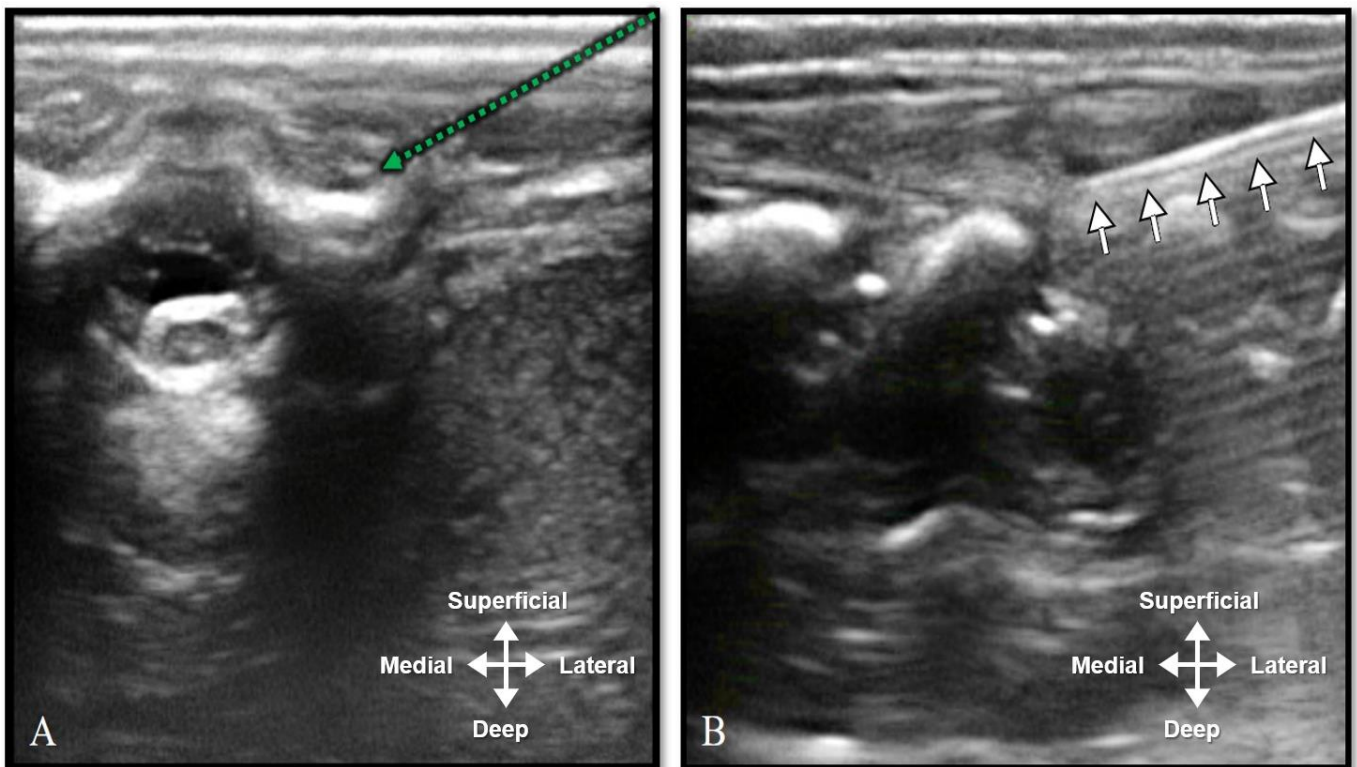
The ultrasound bony landmarks in a transverse (A) and parasagittal orientation (B) taken at vertebral level T5. The green dotted arrow represents the needle course in a transverse alignment, while the white arrows represent the needle course in a parasagittal alignment.
